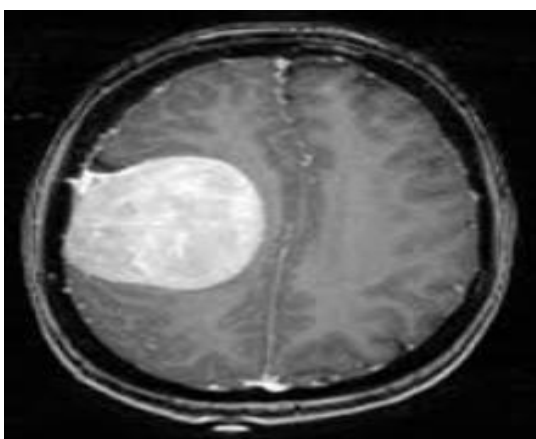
Original Brain MRI Image
